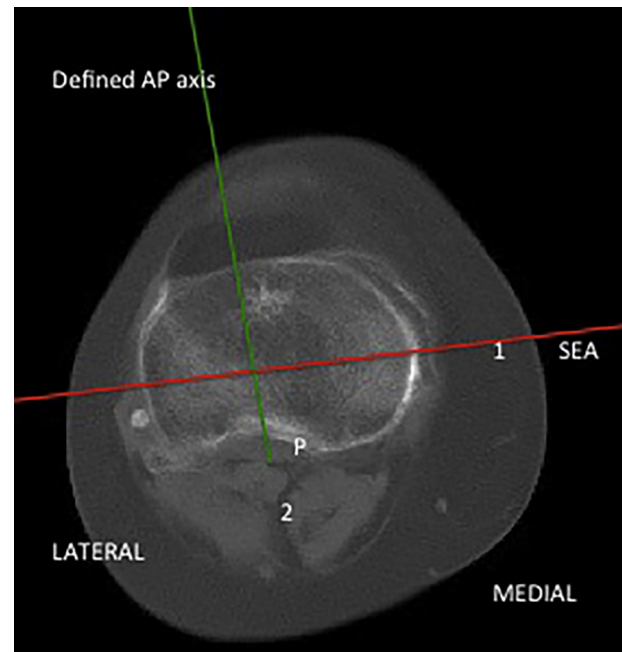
Axial CT image in which line 2 (denoted in Green color) is the defined AP axis. It is perpendicular to line 1 and passes through the center of the posterior cruciate ligament (PCL).
